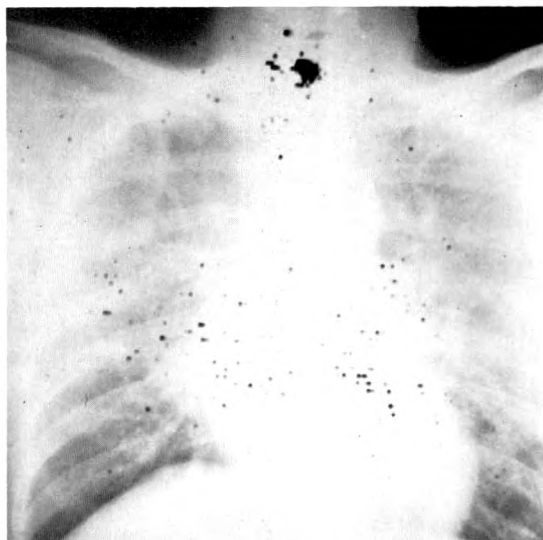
An overlay of a repeat scintiscan on a supine chest roentgenogram. Both the scintiscan and the roentgenogram were obtained with the patient's breasts bound in the midline of the chest. This maneuver demonstrates a shift of the radioactivity to the area of the breasts in the midline.
